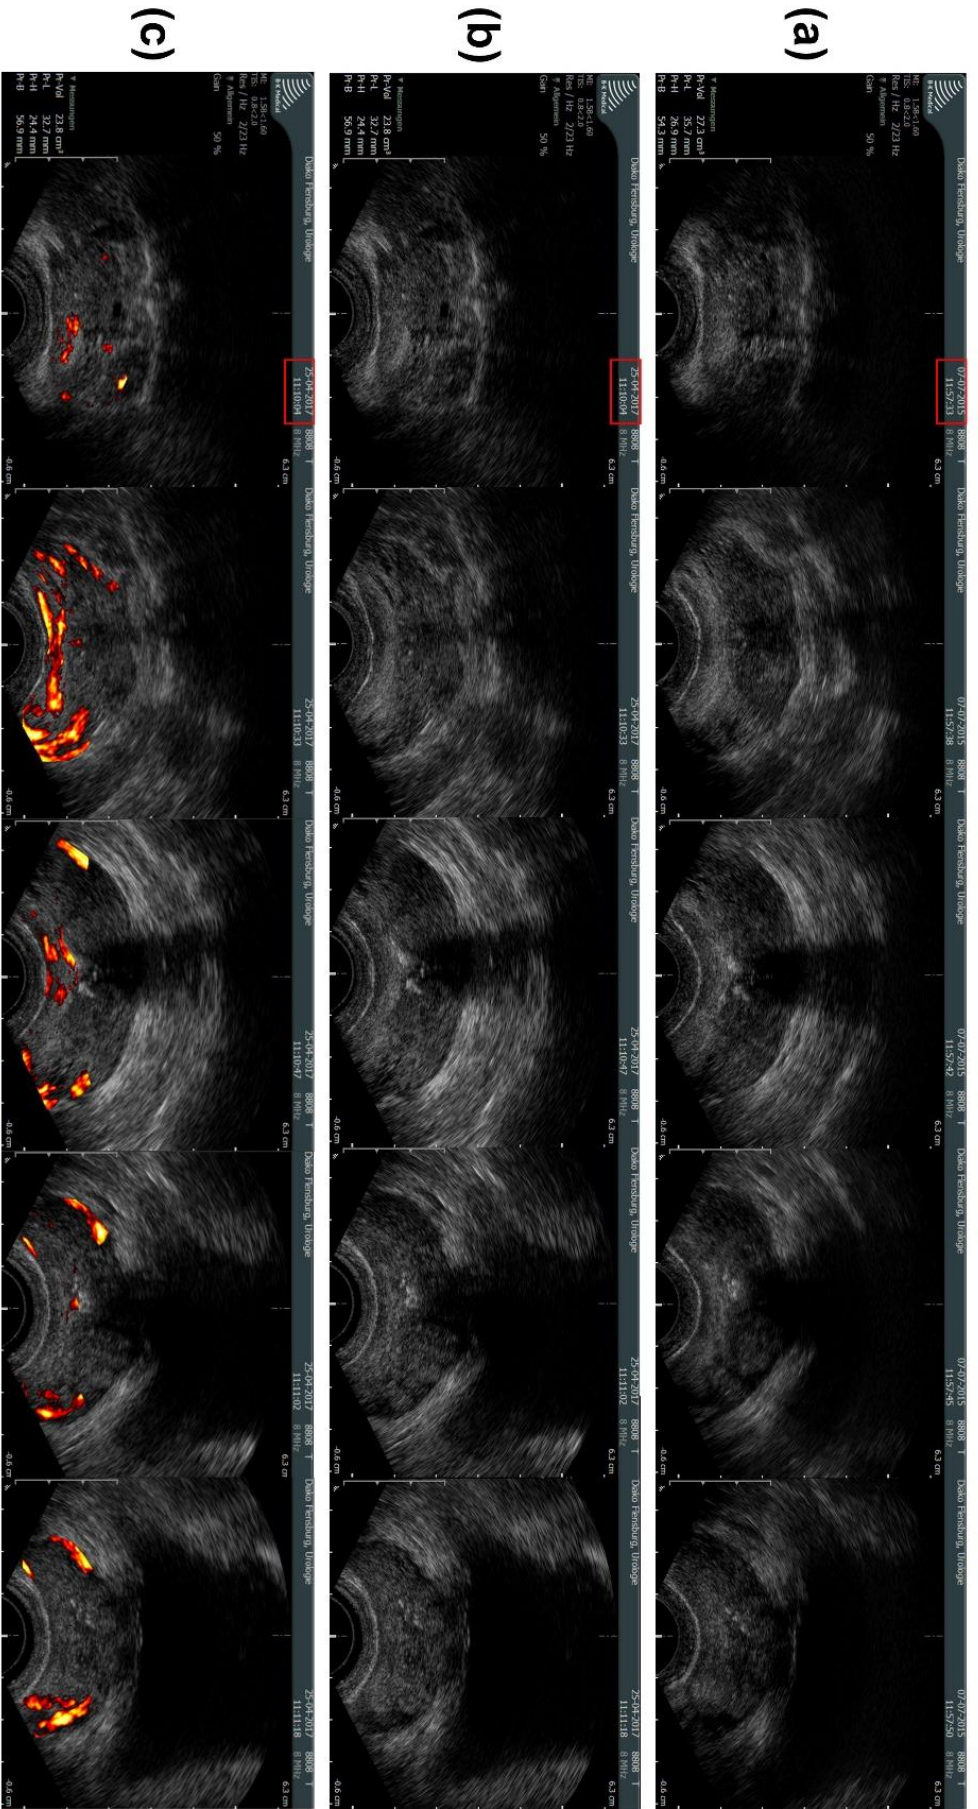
Depiction of AI-US-CT. Two exactly correlated series of TRUS images on (a) 06/2015 and (b) 04/2017. (c) Session of 04/2017 with ANNA/C-TRUS evaluation.
